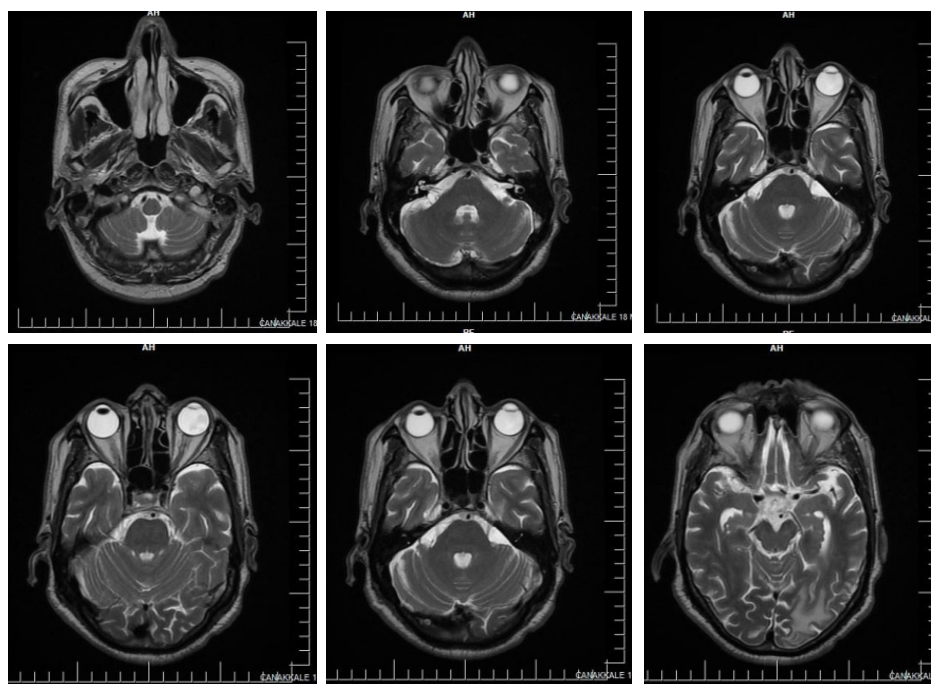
Brain magnetic resonance imaging (MRI) scan T2-weighted image of normal brainstem
